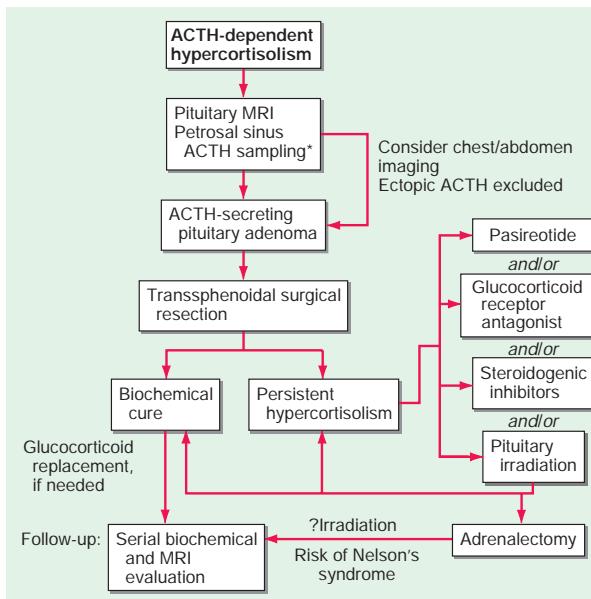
Management of Cushing's disease. ACTH, adrenocorticotropin hormone; MRI, magnetic resonance imaging; \*, Not usually required.
